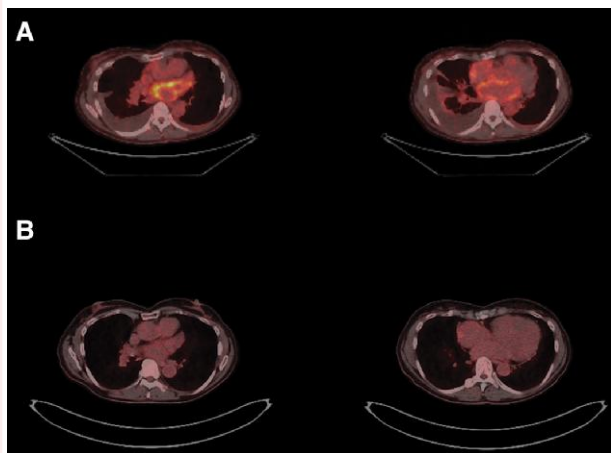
Positron emissions tomography/computed tomography before and after prednisolone treatment. (A) PET/CT before prednisolone treatment. (B) PET/CT after prednisolone administration at two-months follow-up. PET/CT, positron emissions tomography/computed tomography.
